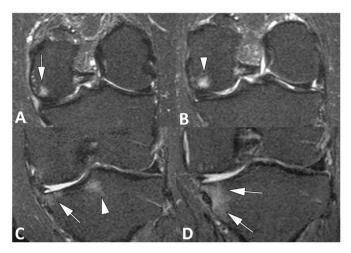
Coronal fat-suppressed proton density-weighted MRI from 60-month (A) and 84-month (B) visits showing a within-grade increase of a grade 1 bone marrow lesion (BML) size located at the central subregion of the medial femoral condyle (arrow – A; arrowhead – B). Although there is an evident increase of BML size between A and B, both lesions do not reach more than 25% of the whole central subregion of the medial femoral condyle area (BML grade must be considered then as grade 1 in the WORMS system for A and B). In another participant, coronal fat-suppressed proton density-weighted MRI from 60-month (C) and 84-month (D) visits show a full-grade increase bone marrow lesion (BML) size located at the central subregion of the medial tibia, involving less than 25% of the whole area in C – grade 1 (arrow), whereas in D it involves between 25% and 50% of the whole area, consistent with a grade 2 (arrows). Note a small BML near the subspinous region at C (arrowhead).
